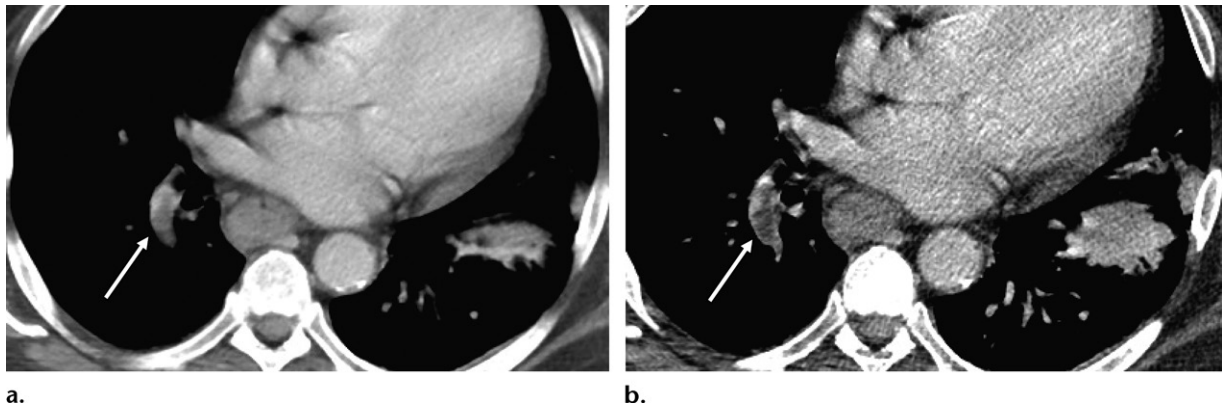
Missed pulmonary embolus in a 44-year-old man with Crohn disease who underwent contrast-enhanced CT in the emergency department for abdominal pain and concern for obstruction. Axial images of 5-mm (a) and 1.25-mm (b) section thickness show an incidental pulmonary embolus in the right lower lobe (arrow), which is more apparent on the 1.25-mm-thick section.
